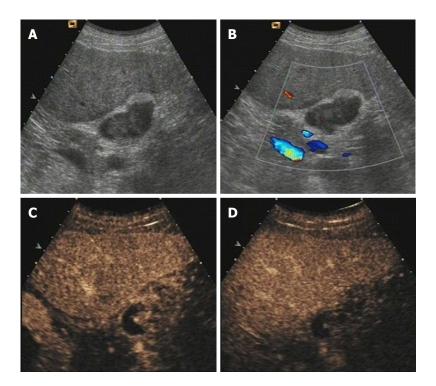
Gallbladder cancer in a 46-year-old male patient. A: B-mode sonography showed a heterogeneously hypoechoic mass in the gallbladder, and the posterior wall of the gallbladder was not very clear; B: Color Doppler ultrasound showed no color Doppler signal in the lesion. According to A and B, a diagnosis of probably malignant was made. C: CEUS showed a heterogeneously hyperenhanced mass with tortuous-type tumor vessel on arterial phase and the boundary of the mass was not clear; D: CEUS showed the enhancement of the lesion is much lower than that of the surrounding gallbladder wall on venous phase. According to C and D, a diagnosis of malignant mass was made. CEUS: Contrast-enhanced ultrasound.
